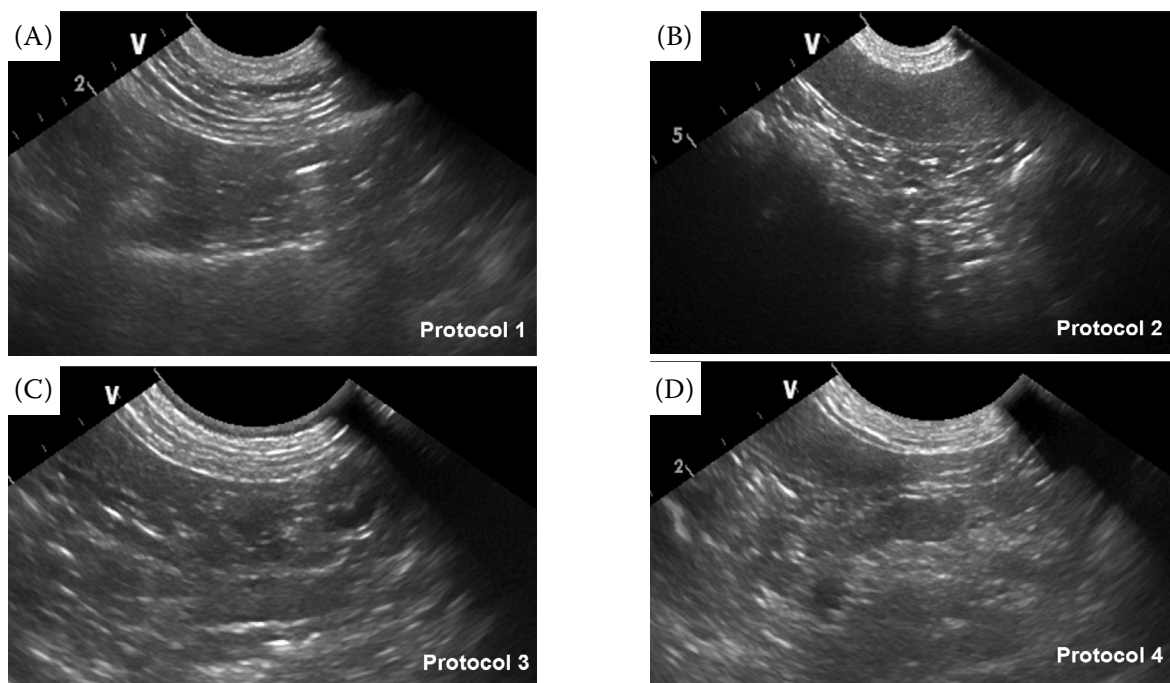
Ultrasonographic (USG) images of the jejunal LN
